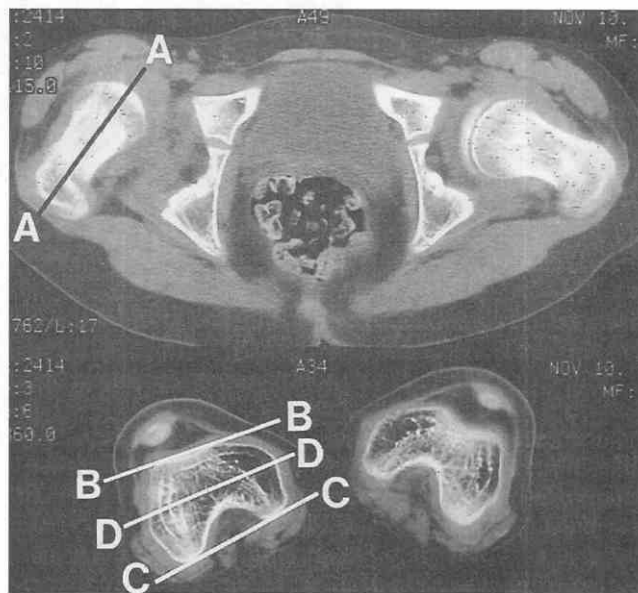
Recurrent right hip dislocation in a 9-year-old girl with cerebral palsy. Axial CT images obtained at the levels of the femoral necks (*top*) and the femoral condyles (*bottom*) are used to measure anteversion. The difference in angulation between the axis of the femoral neck (line A) and the transcondylar axis (line D) gives the angle of anteversion. The transcondylar axis is determined by bisecting the angle formed by tangent lines along the anterior (line B) and posterior (line C) aspects of the femoral condyles. The subluxated right femur is anteverted compared to the left femur.
